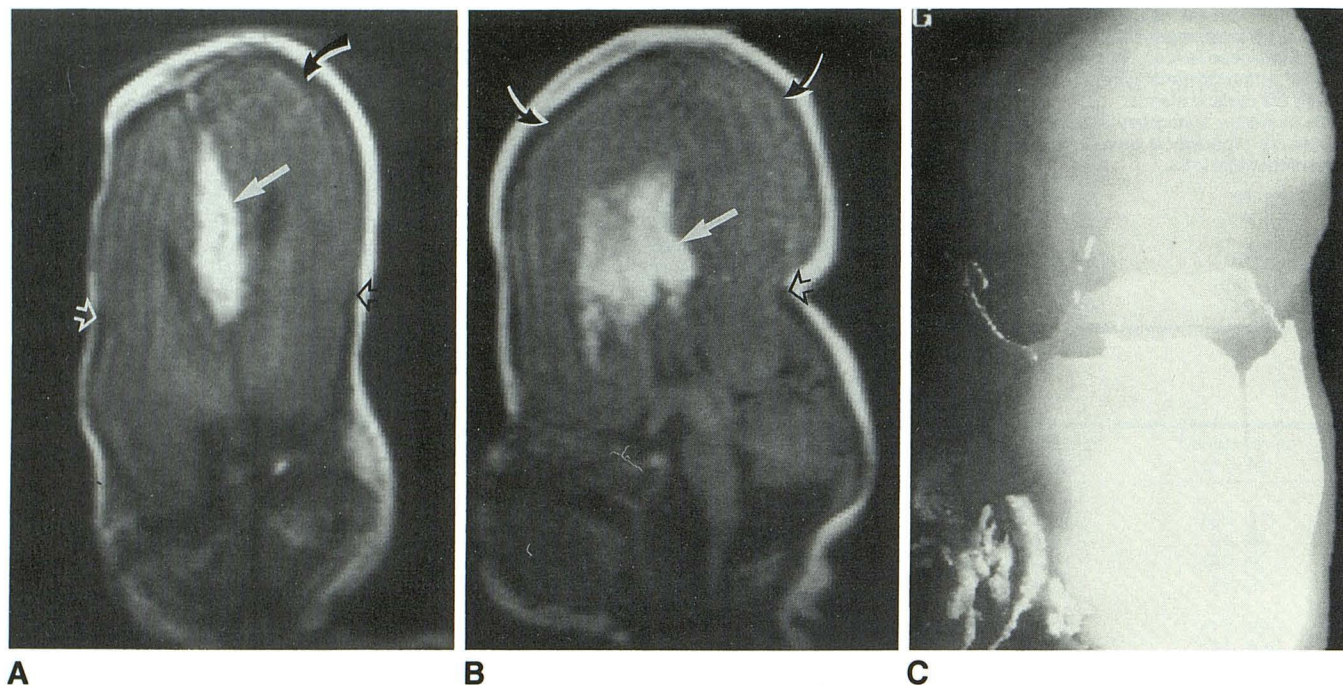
36-week gestational age female infant with a towering encephalocele, agenesis of the corpus callosum, and a midline lipoma. A and B, Coronal (A) and sagittal (B) T1-weighted (500/20) spin-echo MR images. Large white arrows indicate hyperintense lipoma, which occupies the space of the absent corpus callosum. Note elevation of contents of posterior fossa as most of the supratentorial brain has herniated out through the skull defect. Open arrows indicate the hypointense edge of the termination of the skull. The hypointense rim about the herniated brain (curved arrows) is caused by CSF.
